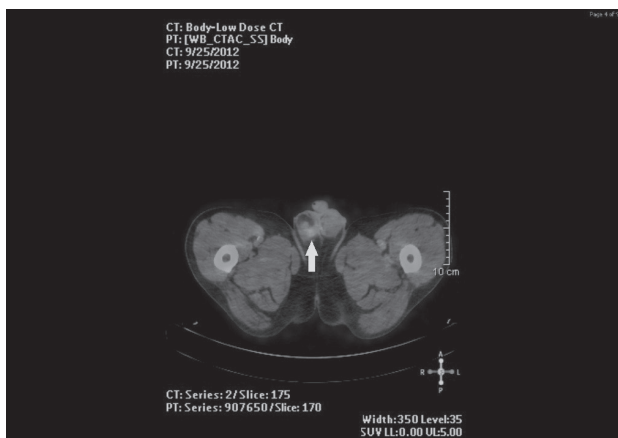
PET scan with FDG radiotracer showed an intense focal FDG uptake in the right hemiscrotal region (green arrow), with no increased FDG accumulation in the regional lymph nodes.
